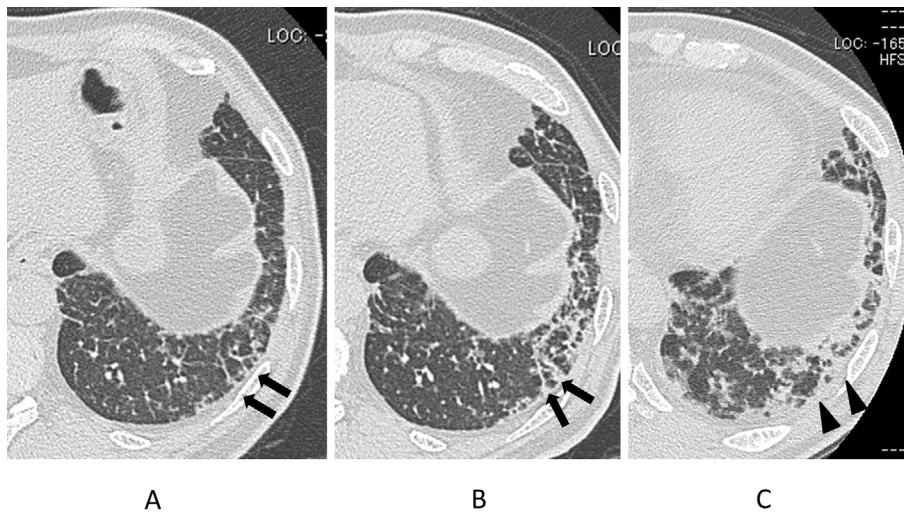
Follow-up CT findings in Case 5. (A) Peribronchovascular opacity (arrows) was observed in the left lower lobes on admission. (B) Follow-up CT 18 days after admission showed the thickening of the peribronchovascular opacity in the left lower lobes (arrows). (C) The peribronchovascular opacity on the left lower lobes progressed to consolidation in about one month (arrowhead).
